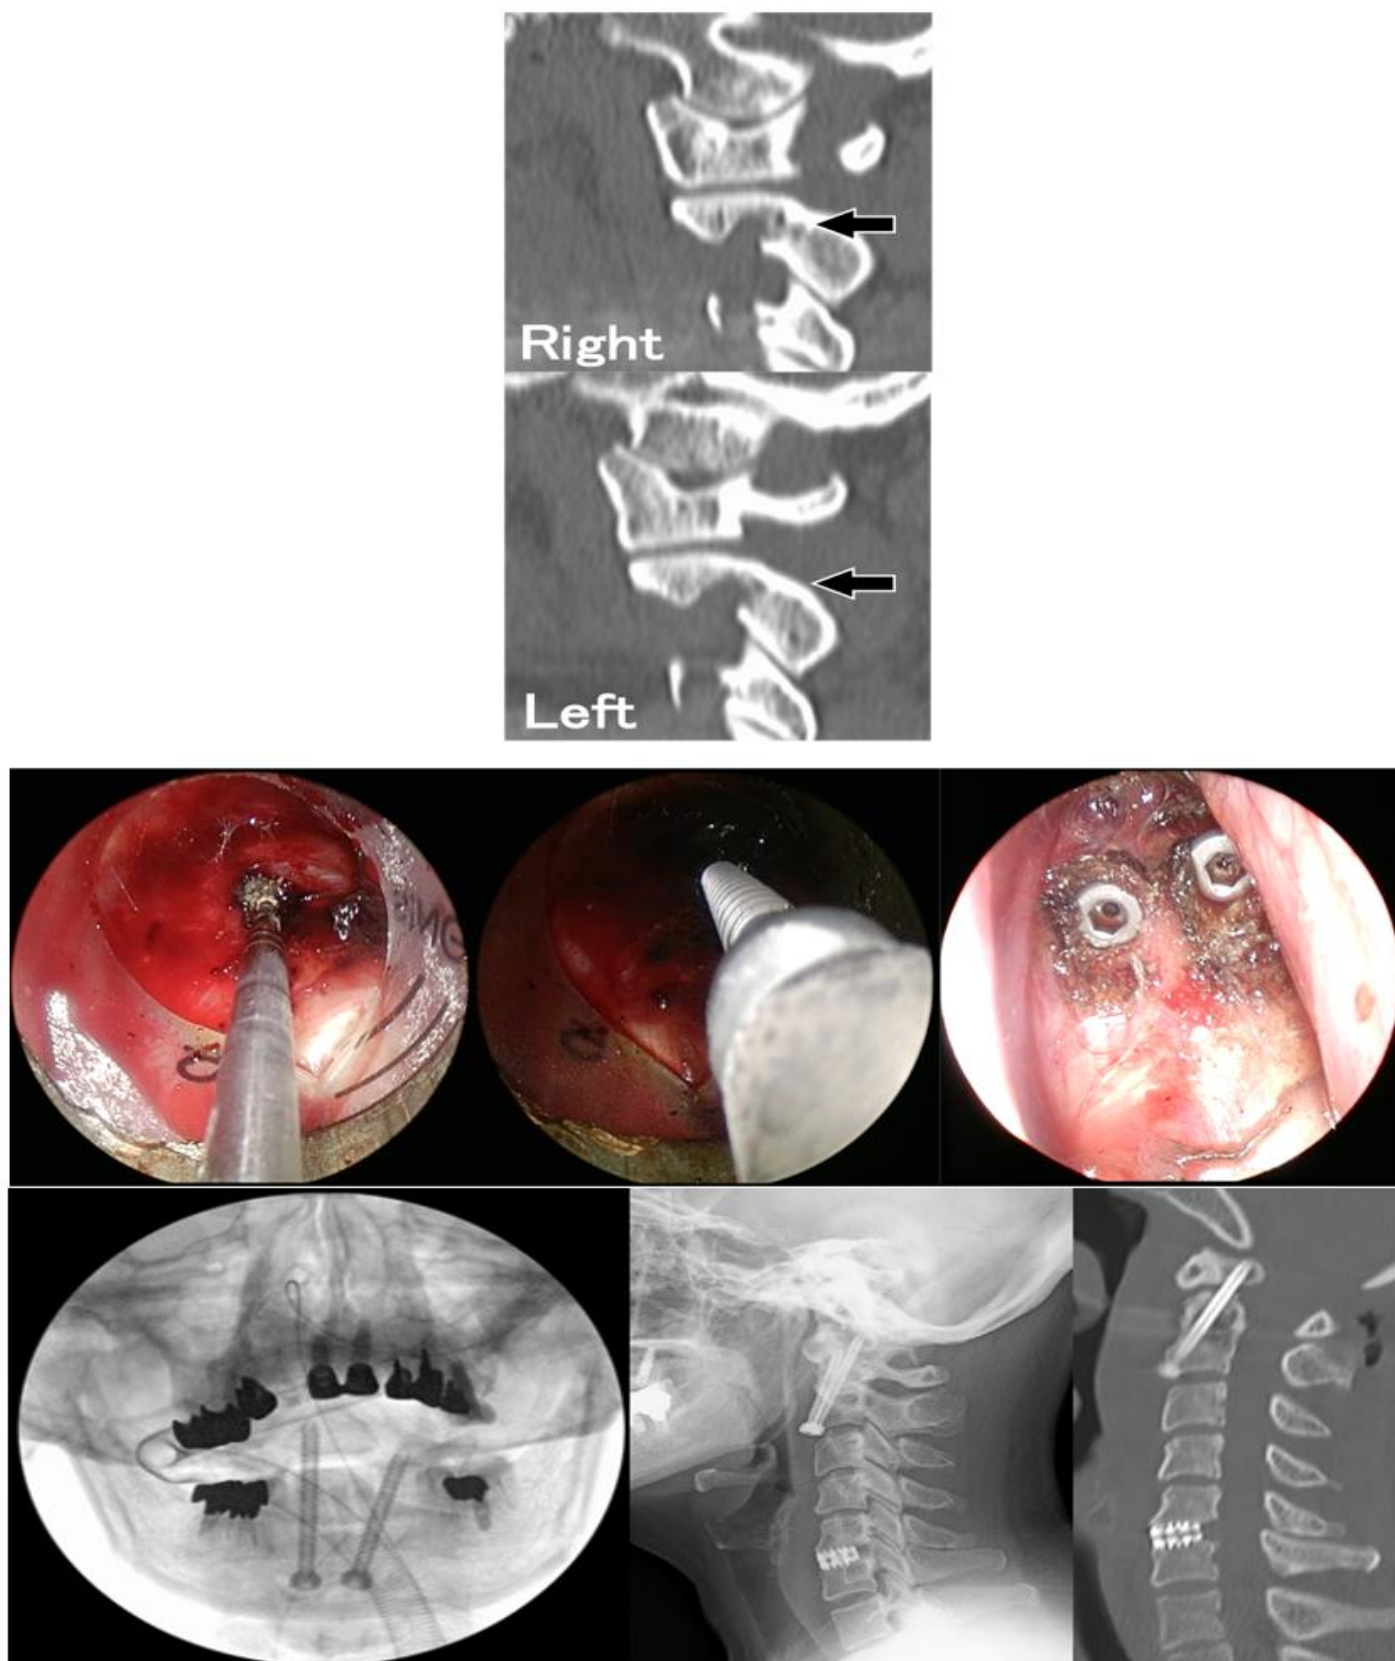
Case of anterior fixation (Case 15 in Table 1). A: Lateral cervical radiographs in flexion (left), neutral (center) and extension (right). The patient had os odontoideum with C1/2 instability; B: Sagittal and axial T2-weighted MRI showing a high-intensity intramedullary signal at the C1/2 level. Spinal cord compression at C5/6 due to an anterior bony spur and disc protrusion is also noted; C: Sagittal CT image showing bilateral high-riding vertebral arteries; D: Intraoperative findings Using navigation and lateral fluoroscopy, a drill hole was created from the anterior surface of C2 for screw placement (left). A
